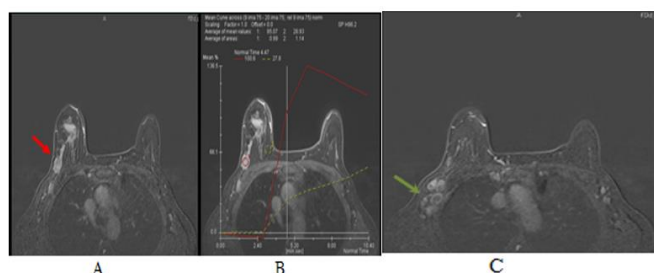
DCE-MRI axial post-contrast view (A)Right UOQ oval speculated mass lesion show heterogeneous enhancement(red arrow), Kinetic curve (B)Rapid initial rise with wash out delayed phase, (C)with axillary lymphadenopathy(green arrow).
